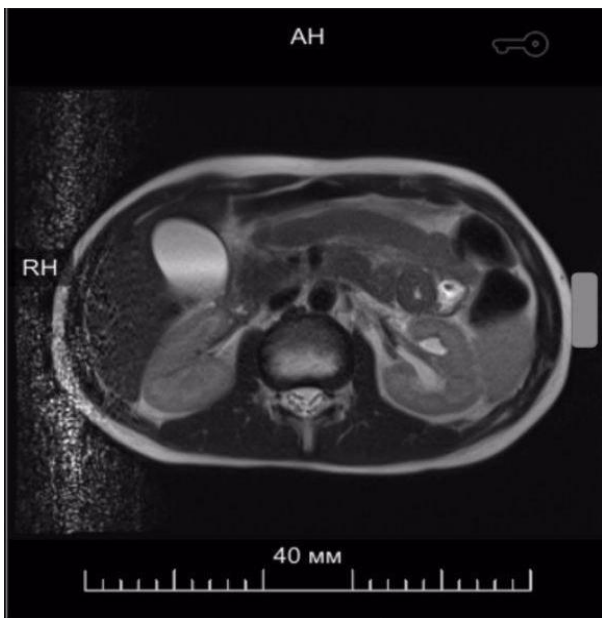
Axial view of MRI of abdomen.
